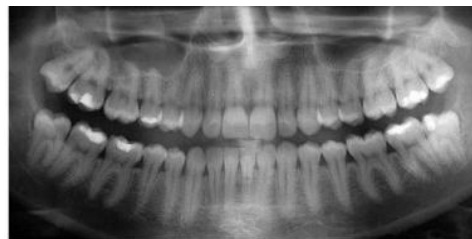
Restored x-ray image
